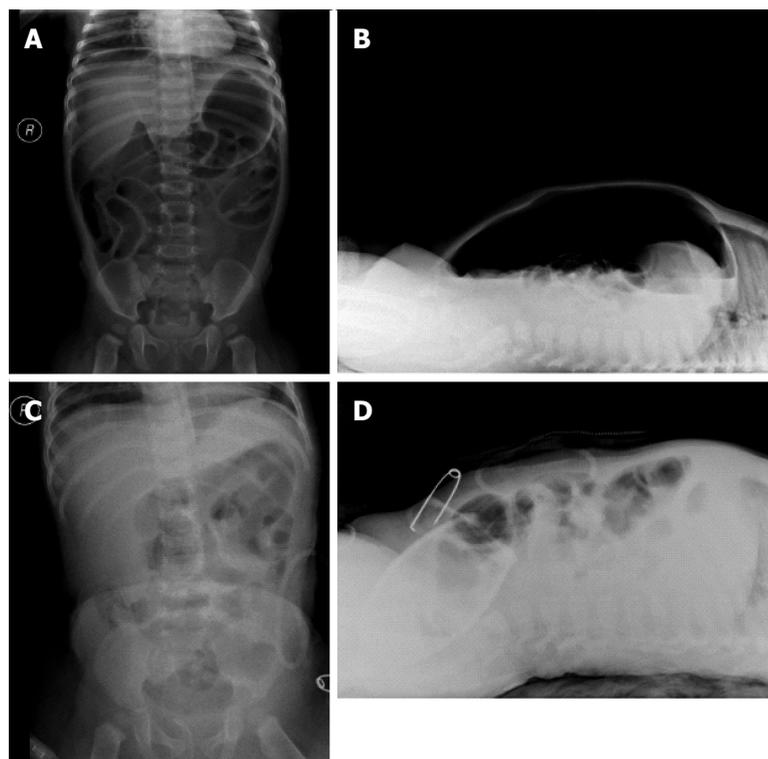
X-ray images of the abdomen. A, B: Images showing the pneumoperitoneum; C, D: Images showing recovery of pneumoperitoneum after intestinal repair.
